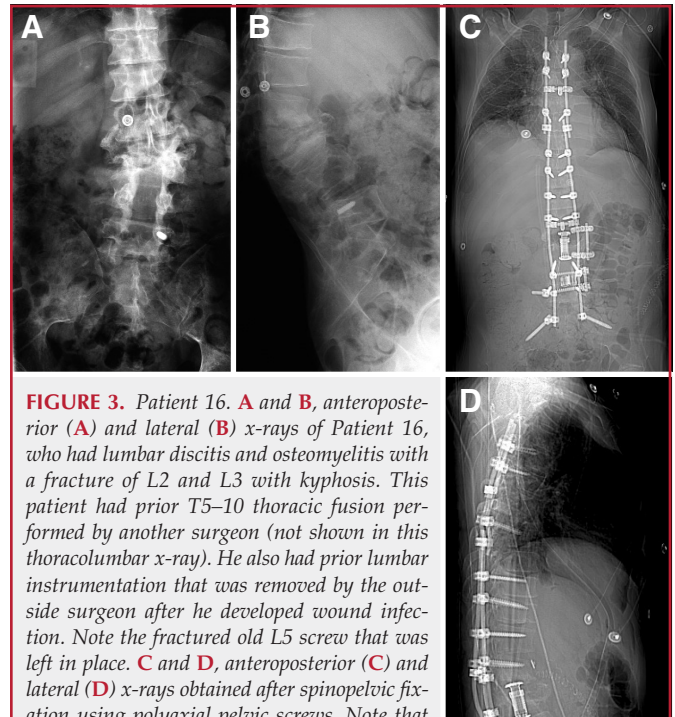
Patient 16. A and B, anteroposterior (A) and lateral (B) x-rays of Patient 16, who had lumbar discitis and osteomyelitis with a fracture of L2 and L3 with kyphosis. This patient had prior T5–10 thoracic fusion performed by another surgeon (not shown in this thoracolumbar x-ray). He also had prior lumbar instrumentation that was removed by the outside surgeon after he developed wound infection. Note the fractured old L5 screw that was left in place. C and D, anteroposterior (C) and lateral (D) x-rays obtained after spinopelvic fixation using polyaxial pelvic screws. Note that one polyaxial pelvic screw is linked directly to the lumbosacral rod without a connector and the other is linked with the use of an offset connector (Expedium; Depuy Spine, Raynham, MA). Domino connectors linked the new T11-to-iliac construct with the T5–10 construct from the patient's prior surgery. The patient also underwent corpectomies of L2 and L3 and ALIF with cage and anterior screw-rod construct at L4–L5.
